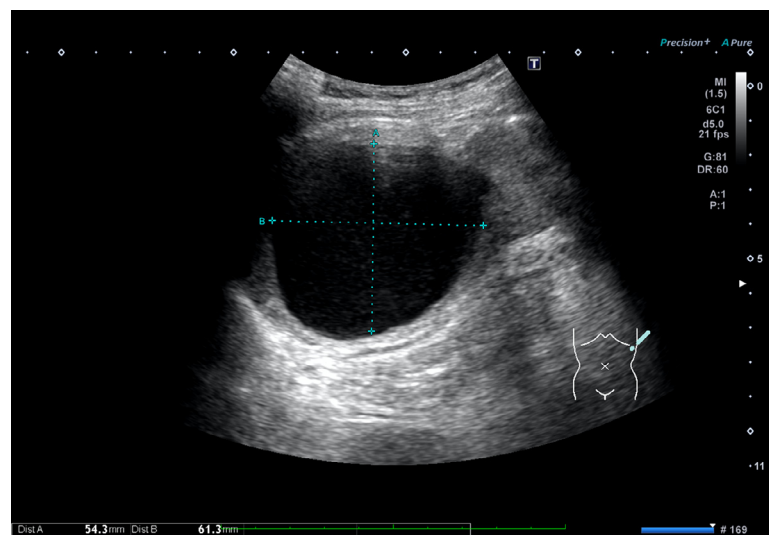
Ultrasound shows that the cyst remained in shrunken size at 6 months after second session.
